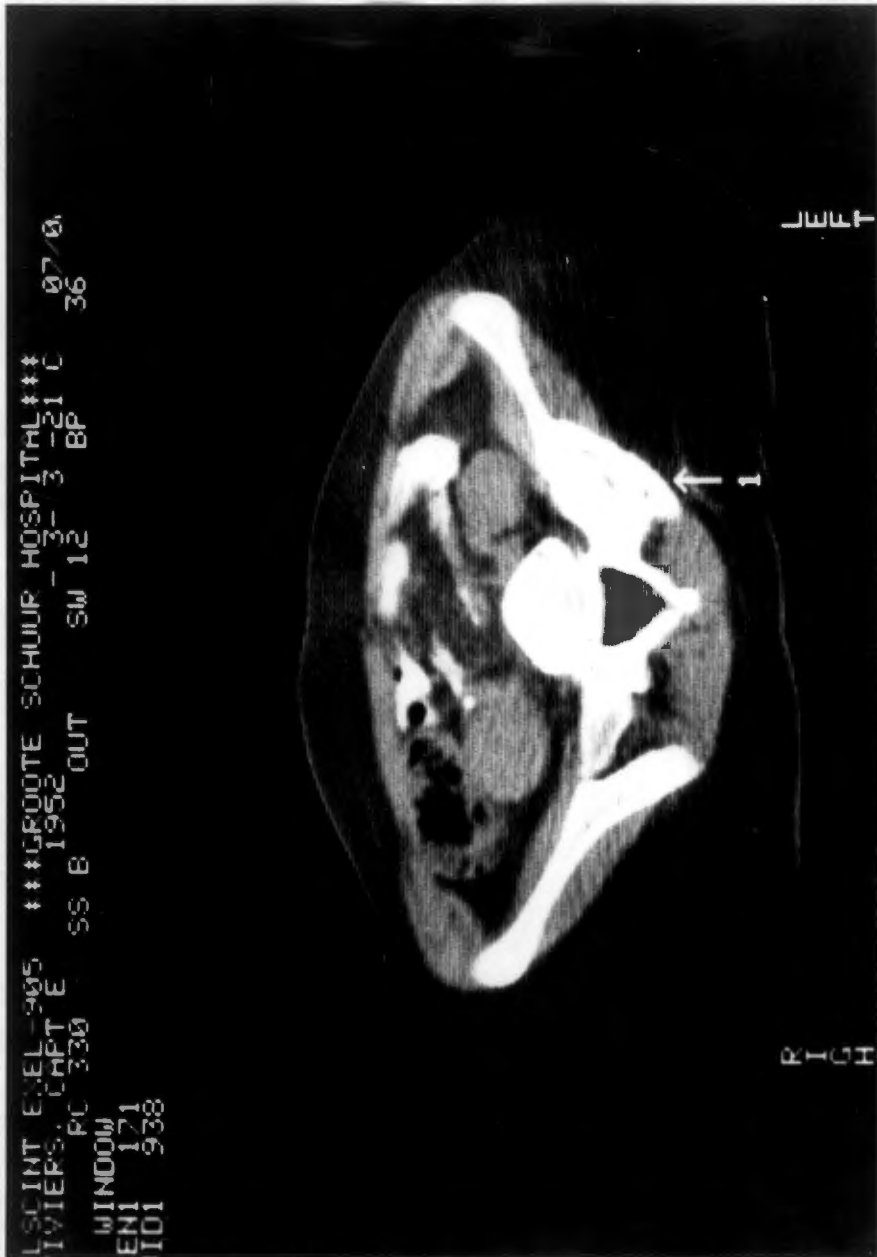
CT scan showing the osteoclastoma of the left wing of the sacrum. Note the atrophy of the psoas muscle.
